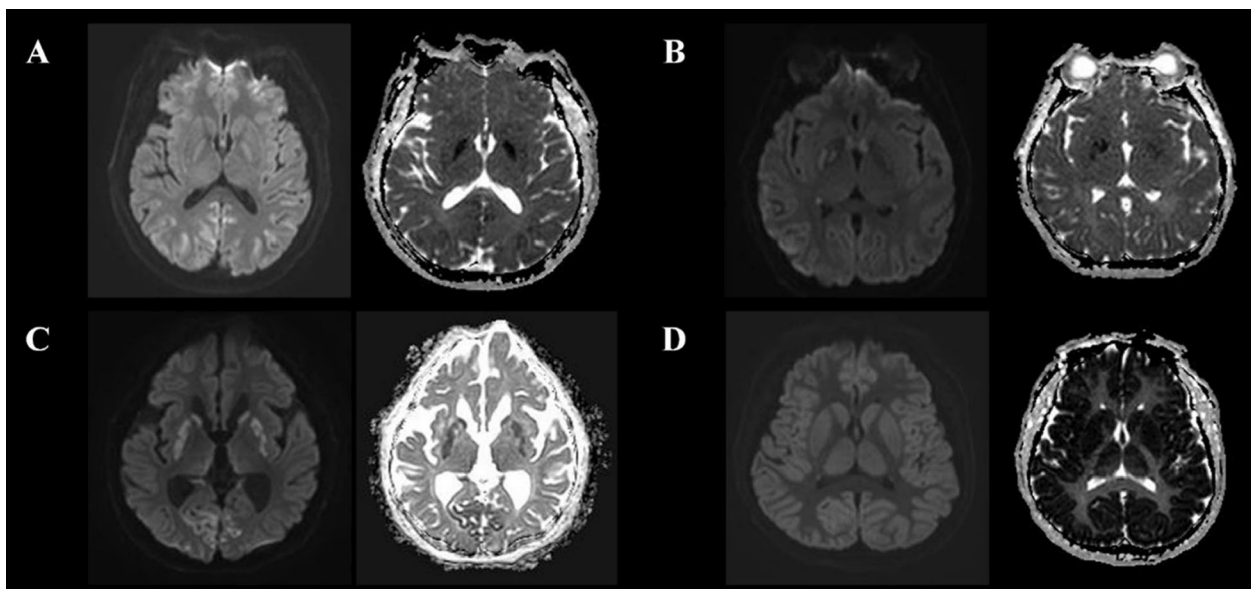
Various pattern of ultra-early DW-MRI and ADC of OHCA survivors. A. A 70-years old male. Gyrform restrictive diffusion in occipital cortex. B. A 31-years old female. Gyrform and regional restrictive diffusion in occipital cortex, temporal cortex, and deep gray matter, respectively. C. A 74-years old male. Gyrform and regional restrictive diffusion in occipital cortex and deep gray matter, respectively. D. A 58-years old male. Extensive gyrform restrictive diffusion in all gray matter. *Abbreviations:* OHCA, out-of-hospital cardiac arrest; DW-MRI, diffusion-weighted magnetic resonance imaging; ADC, Apparent diffusion coefficient
